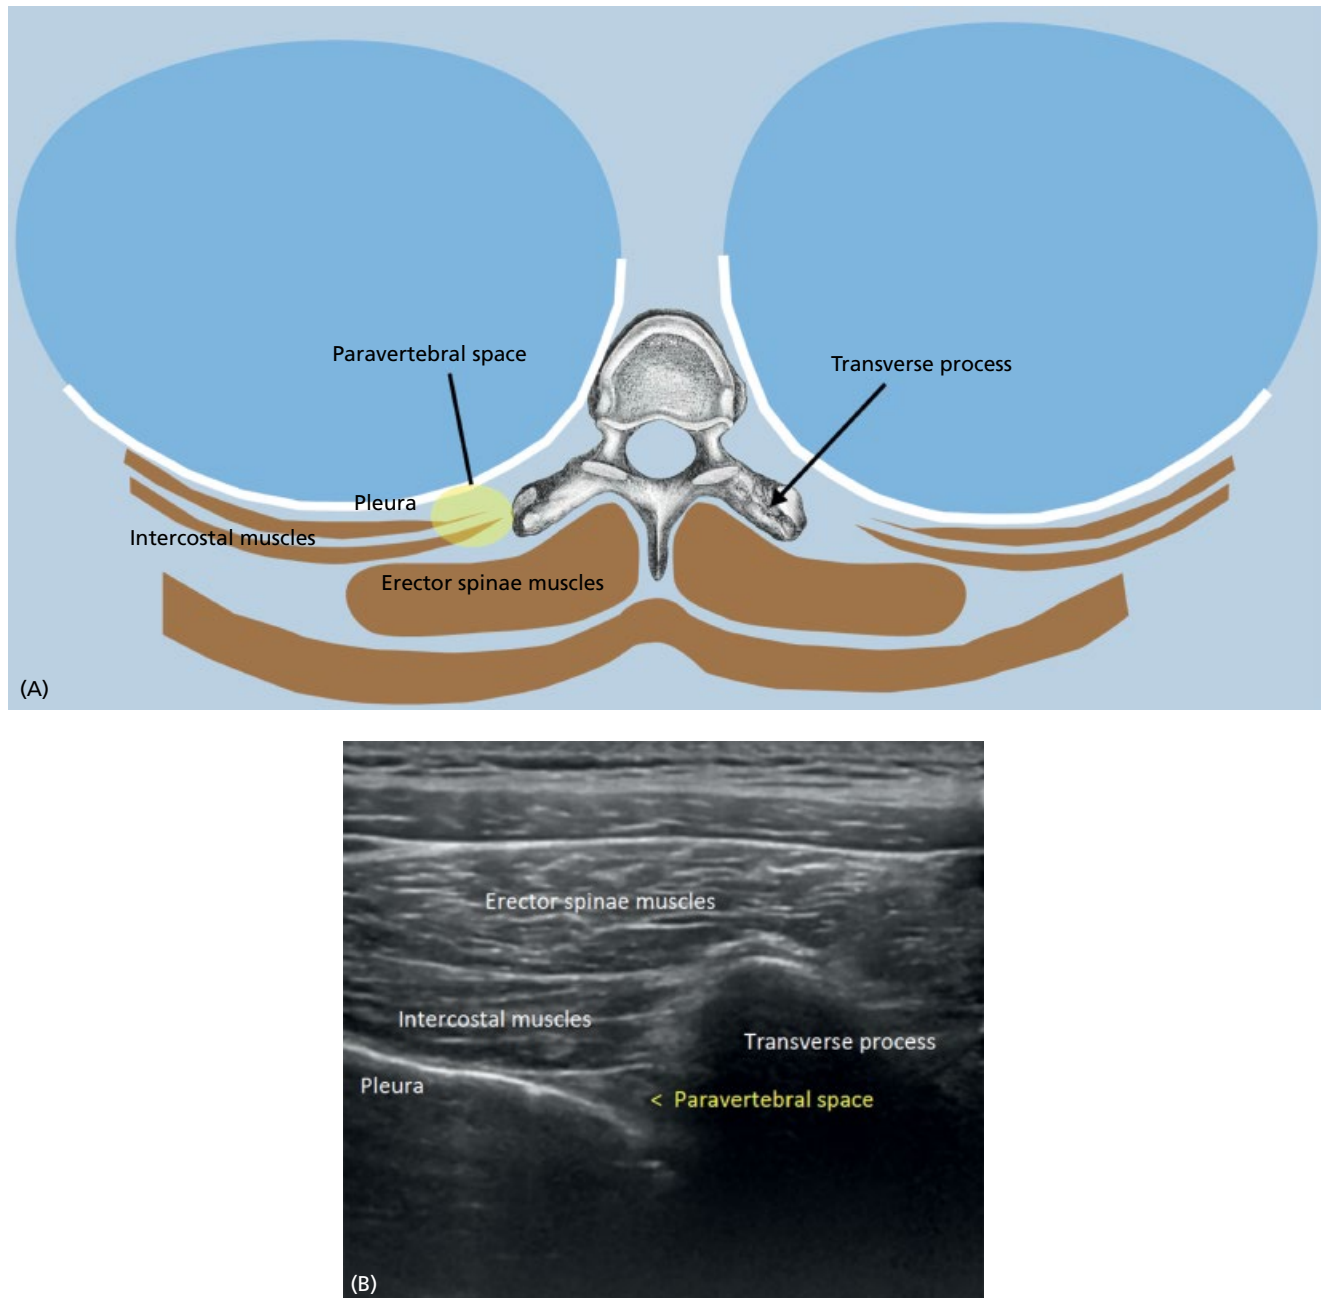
The paravertebral region. (A) Ultrasound anatomy. The paravertebral space is a wedge-shaped area positioned between the heads and necks of the ribs. The superior costotransverse ligament forms its posterior wall, the anterolateral wall is the parietal pleura with the endothoracic fascia, and the medial wall is the lateral surface of the vertebral body and intervertebral disk. (B) Ultrasound image. See text for further details. *Source:* Reproduced from O Riain et al [165] with permission of Wolters Kluwer.
